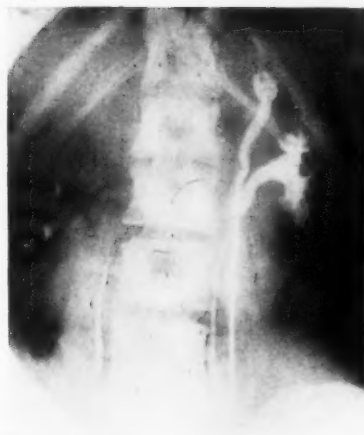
Upper urinary tract of Case II. On right side pelvis is incompletely filled, two calyces showing. On left side is beautifully shown upper point of crossing of duplicated ureters, each leading to an independent pelvis, the lower being entirely normal and the other typically rudimentary in appearance. (X-ray work by Dr. A. L. Gray, Richmond, Va.)
